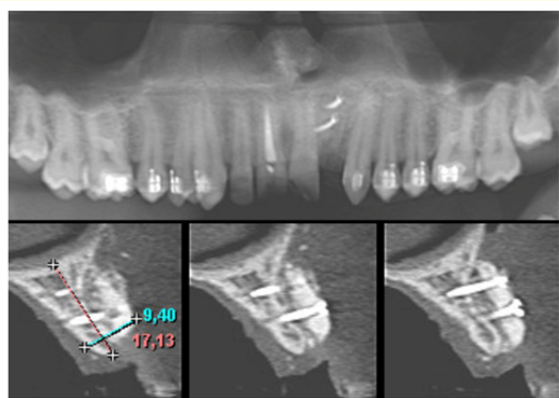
CT scan six months after reconstruction.
